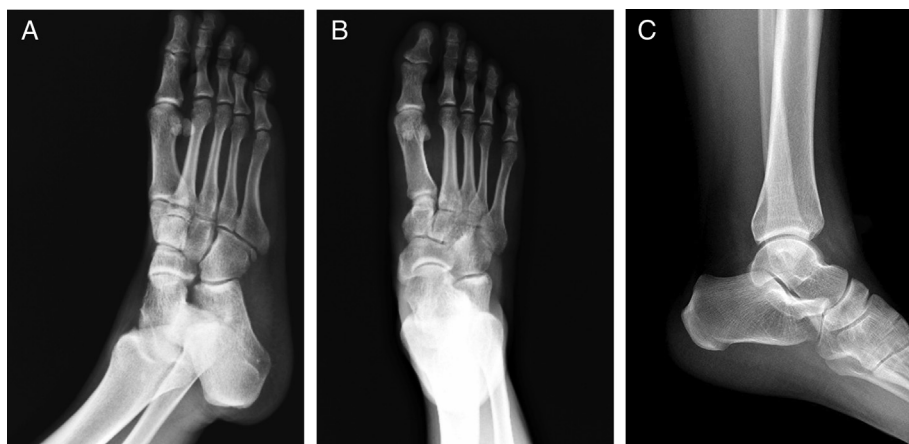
(A) Oblique, (B) anteroposterior, and (C) lateral radiographs of a 27-year-old female with recurrent peroneal spastic flatfoot showed no signs of bone coalition.
